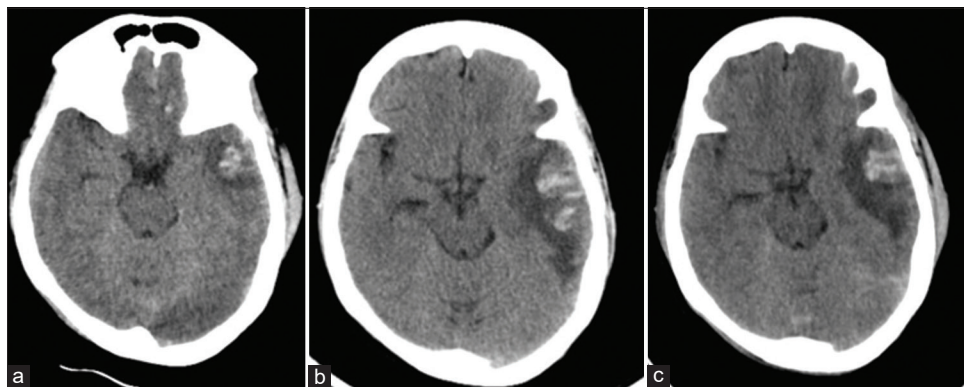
(a) Non-contrast computed tomography (CT) showing small left temporal contusion. (b) CT performed after the onset of disabling headache showing blooming of contusion and increase in the perilesional edema with partial effacement of basal cisterns. (c) CT done 5 days after steroid administration showing resolution of cerebral edema.
